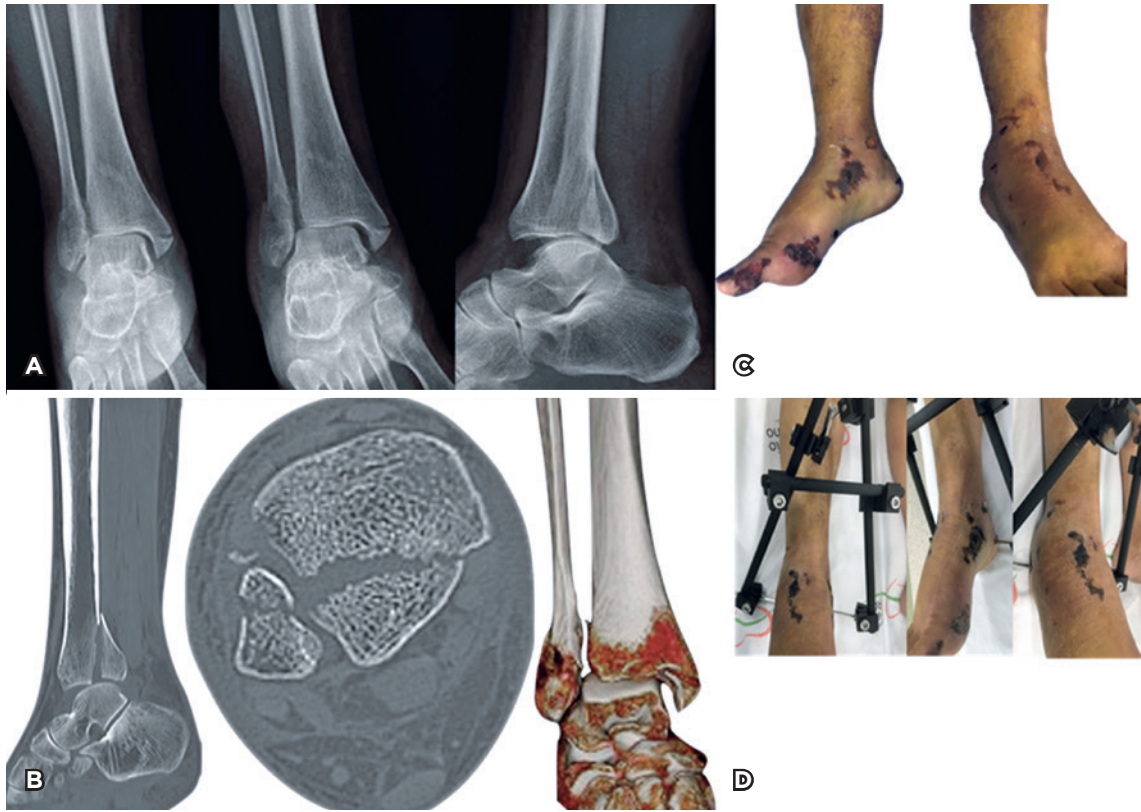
(A) Radiographs of the right ankle in anteroposterior and lateral views show the trimalleolar fracture-dislocation. Observe the reverse obliquity pattern of the medial malleolus. (B) Observe the sagittal, the axial, and the 3D reconstruction of the computed tomography scan showing the trimalleolar fracture dislocation. Observe the reverse oblique pattern of the medial malleolus. (C) Observe the clinical aspect of the right foot/ankle with edema and hemorrhagic blisters. (D) The right ankle was reduced and spanned. Note the presence of the wrinkle sign on the skin 12 days postoperatively, indicating improved soft tissue condition.
